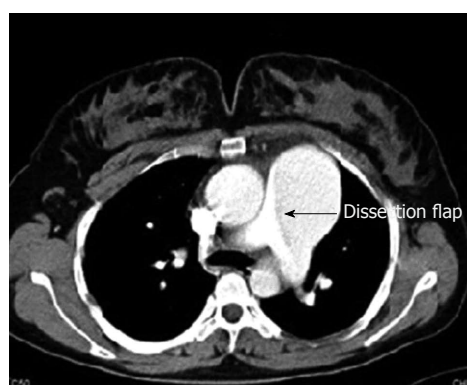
Computed tomography views of pulmonary dissection.
